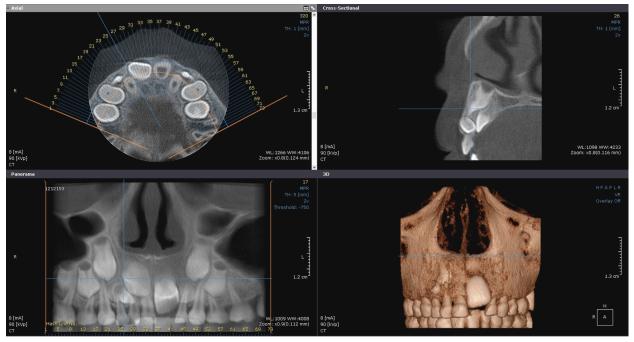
CBCT image with axial, sagittal and coronal views and indirect volumetric rendering image showing the supranumerary tooth in the right upper jaw erupting and blocking the eruption of the central incisor. CBCT: Conebeam computed tomography.
